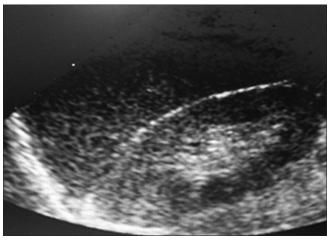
Longitudinal sonogram of the right kidney showing grade I renal echogenicity in a patient with HIVAN
